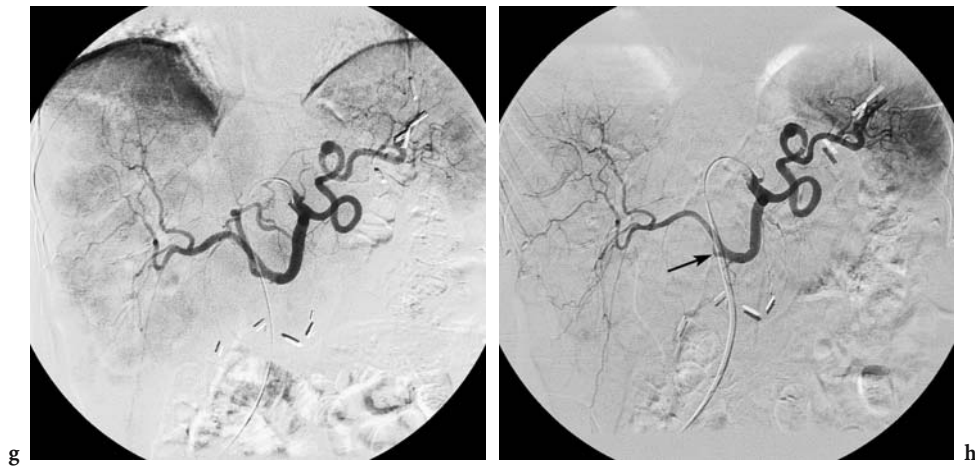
Fifty-six-year-old female with nonfunctioning rectal carcinoid tumor metastatic to liver, complained of upper abdominal pain and hormonal symptoms. (a) Pre-embolization venous-phase CT image of the liver shows the largest metastasis in the left lobe (*arrow*). (b) CT image without intravenous contrast injection, obtained immediately after LHA embolization using 4.5 vials of tris-acryl gelatin microspheres, shows retained arterially injected contrast within the largest metastasis (*arrow*). (c) Venous-phase CT image 3 days post-embolization shows decreased attenuation and a small amount of gas within the largest metastasis, consistent with necrosis. (d) Venous phase CT image 3 months post-embolization shows a significant decrease in size of the largest metastasis, but growth of a new metastasis in the caudate lobe (*arrow*)
